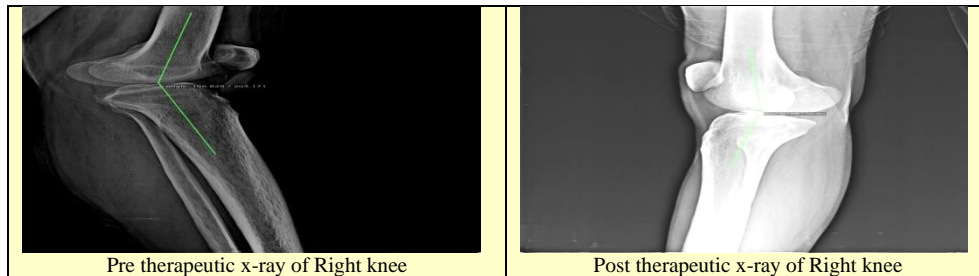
Shows Patient 4 Pre vs. Post Therapeutic X-ray of Right Knee
